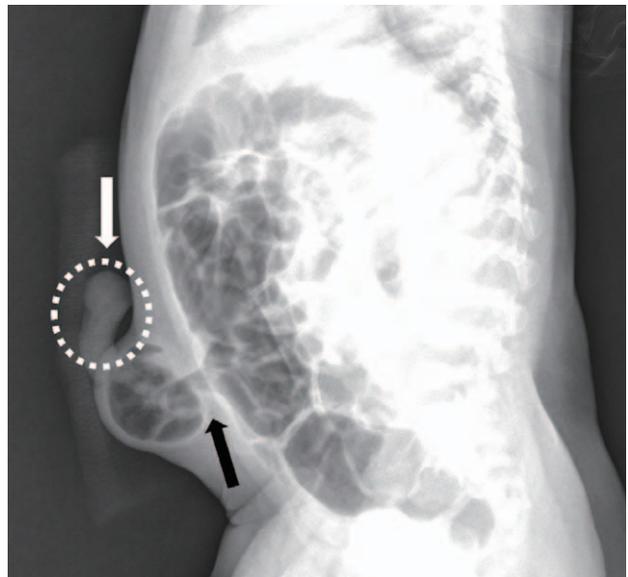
A plain radiograph showing an umbilical hernia (black arrow) with a radiopaque protruded omentum (white arrow).
